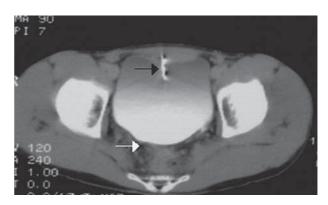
Contrast-enhanced CT of the abdomen shows one metallic nail (black arrow) inserted through the suprapubic region into the urinary bladder with minimal fluid accumulation in the rectovesical pouch (white arrow).
